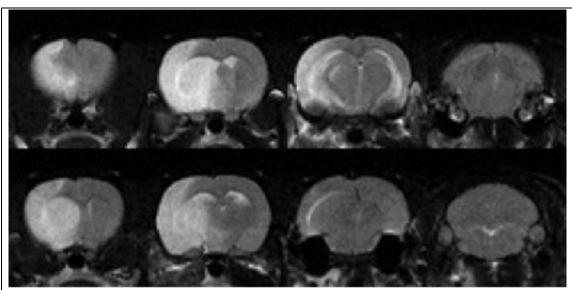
T2-weighted images are used to identify the brain anatomy. Here 24h post reperfusion images show the hyperintense ischemic lesion with ispilateral swelling and midline shift.
